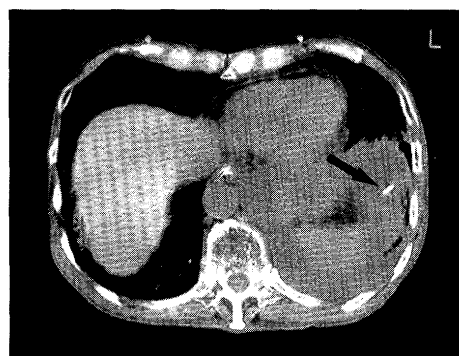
CT scan of the chest demonstrating diaphragm perforation (arrow head)
